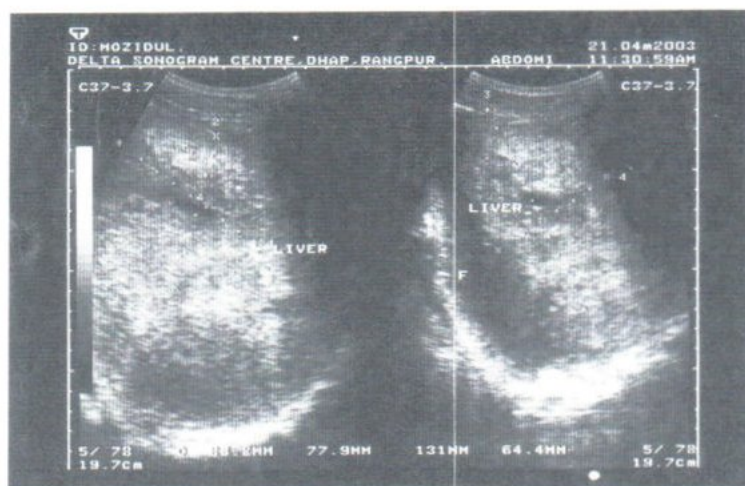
Sonographic Printout of Lacerated liver
